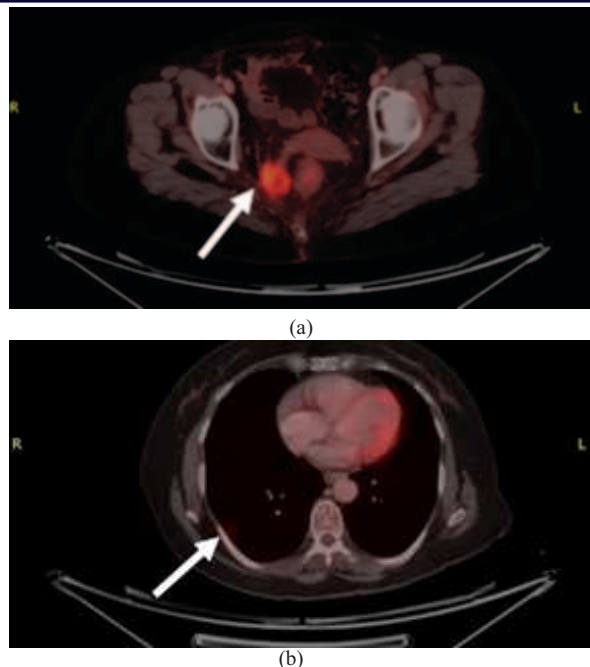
PET-CT showing lesions in (a) The right pararectal region. (b) The lower lobe of right lung.
